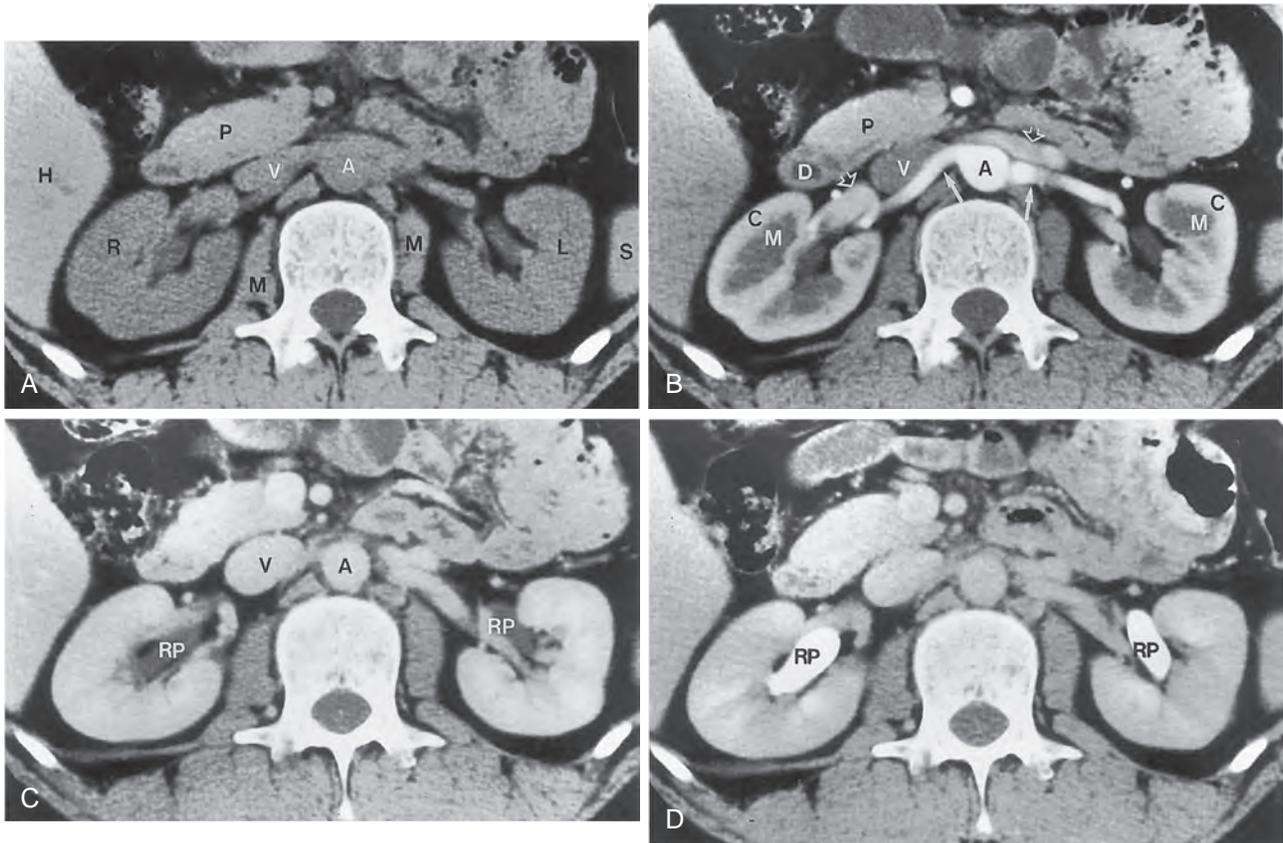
Renal CT demonstrating normal nephrogenic progression. (A) Unenhanced CT scan obtained at the level of the renal hilum shows right (*R*) and left (*L*) kidneys of CT attenuation values slightly less than those of the liver (*H*) and pancreas (*P*). *A*, Abdominal aorta; *M*, psoas muscle; *S*, spleen; *V*, inferior vena cava. (B) Enhanced CT scan obtained during a cortical nephrographic phase, generally 25 to 80 seconds after contrast medium injection, reveals increased enhancement of the renal cortex (*C*) relative to the medulla (*M*). The main renal artery is indicated with *solid arrows* bilaterally. Main renal veins (*open arrows*) are less opacified with respect to the aorta (*A*) and arteries. *D*, Duodenum; *P*, pancreas; *V*, inferior vena cava. (C) CT scan obtained during the homogeneous nephrographic phase, generally between 85 and 120 seconds after contrast medium administration, reveals a homogeneous, uniform, increased attenuation of the renal parenchyma. The wall of the normal renal pelvis (*RP*) is paper thin or not visible on the CT scan. *A*, Abdominal aorta; *V*, inferior vena cava. (D) CT scan obtained during the excretory phase shows contrast medium in the *RP* bilaterally; this starts to appear approximately 3 minutes after contrast medium administration.
